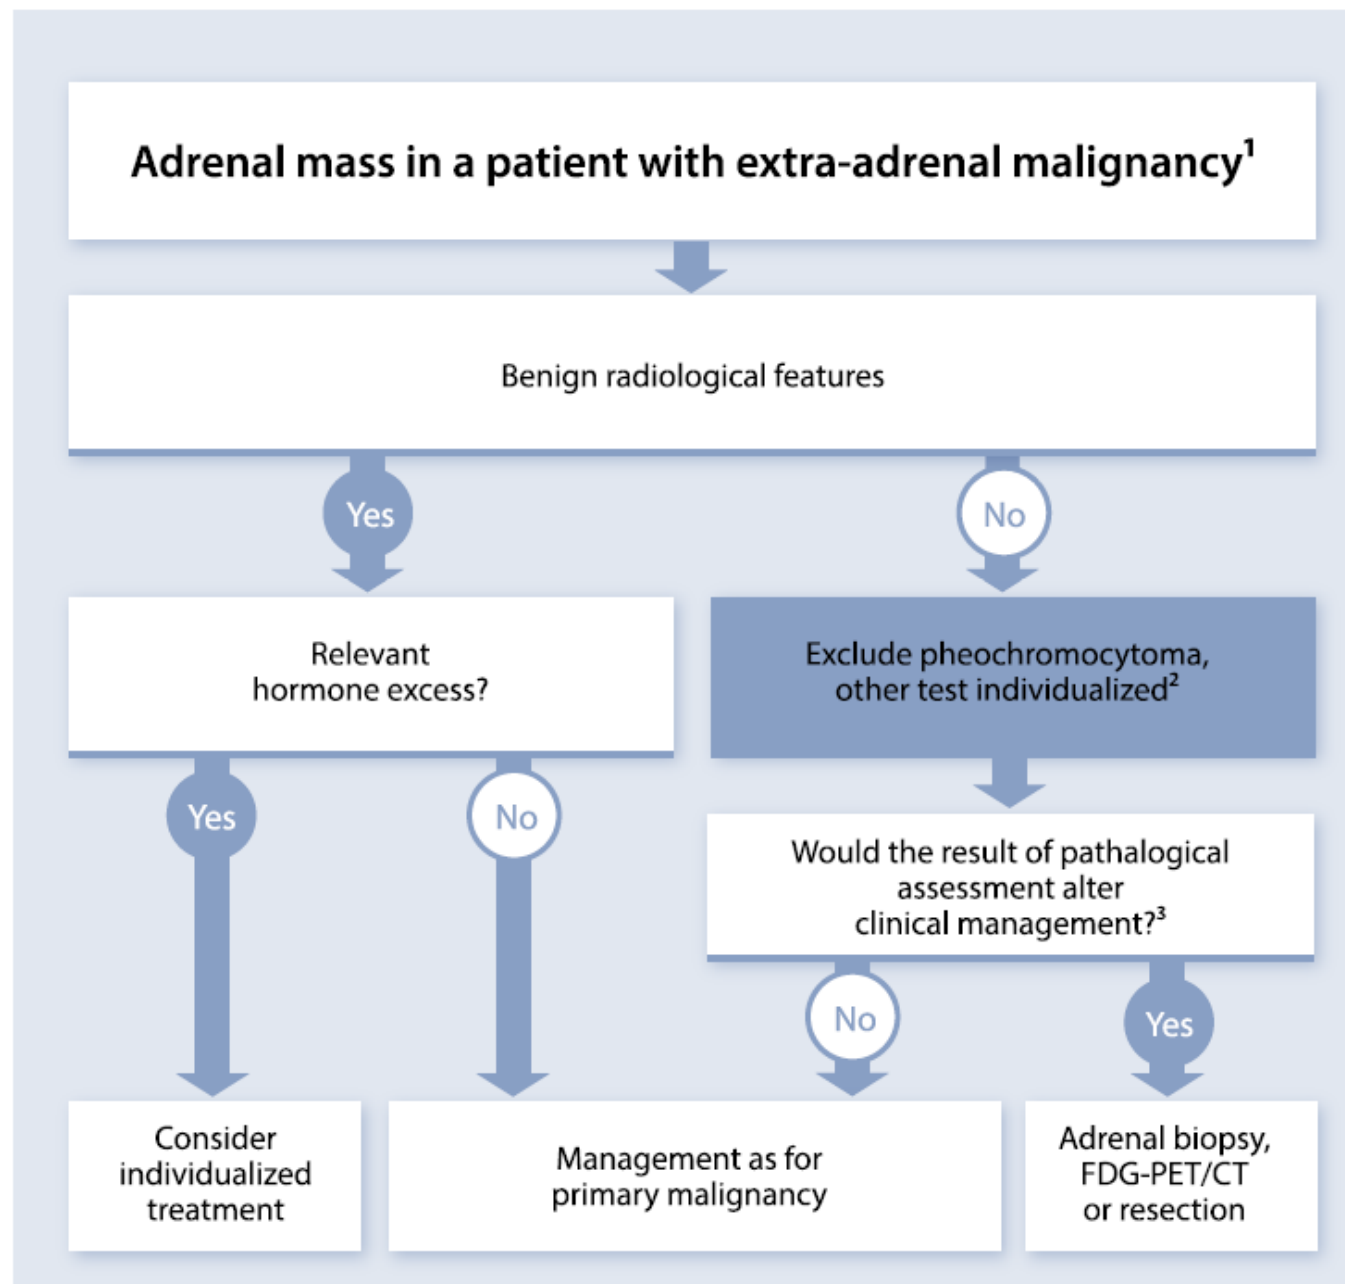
Evaluation of patients with adrenal mass and known extra-adrenal malignancy. ¹Always take life expectancy in consideration. ²If there is hormone excess, treat individualized. ³FDG-PET/CT should be considered to exclude other metastatic deposits in patients with no other obvious metastatic lesions for whom surgical removal of the lesion is an option.
